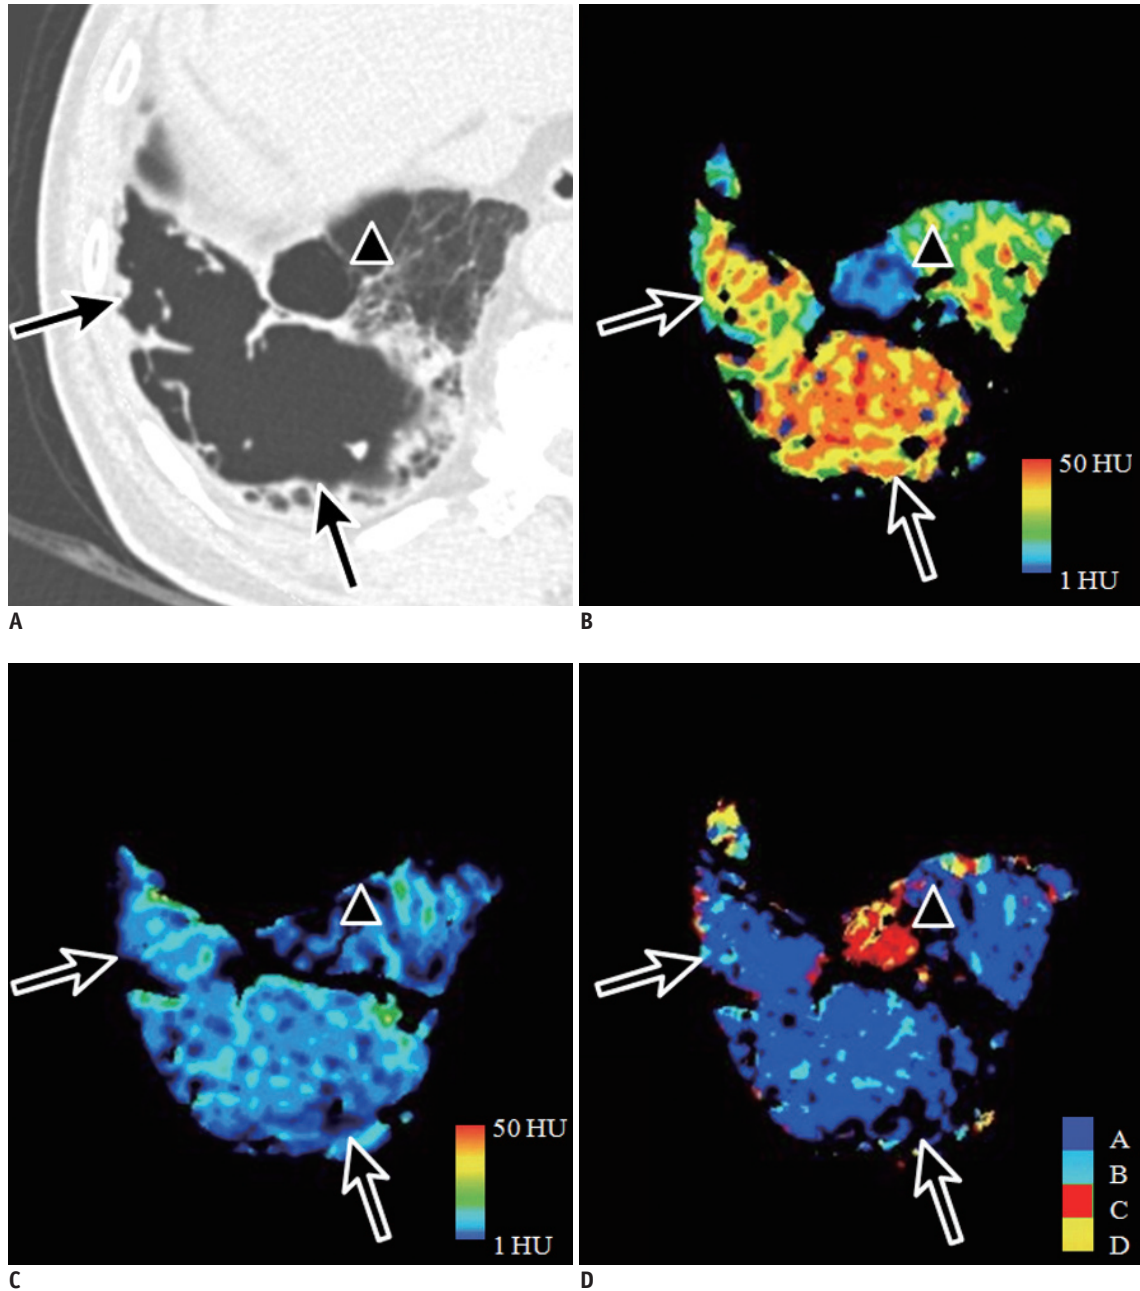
Representative images of patterns A and C for structural abnormalities in 64-year-old male with Gold stage I emphysema. Large subpleural bulla in right basal lung on CT (A; arrows) shows high attenuation on wash-in xenon-enhanced image (B) and iso-attenuation on wash-out xenon-enhanced image (C). This ventilation pattern is compatible with pattern A shown on CAC map in blue (D). Small subpleural bulla anterior to large bulla on CT (A; arrowhead) shows low attenuation on wash-in (B) and wash-out xenon-enhanced images (C). This ventilation pattern is in agreement with pattern C and is correctly visualized on CAC map in red (D). CAC = computer-aided classification
